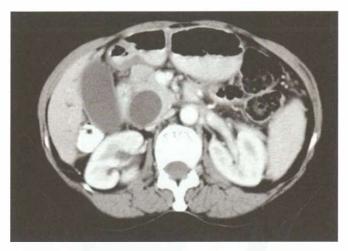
CT scan showing hugely distended gall bladder and common bile duct—periampullary carcinoma. Growth was resectable. He underwent Whipple's operation
